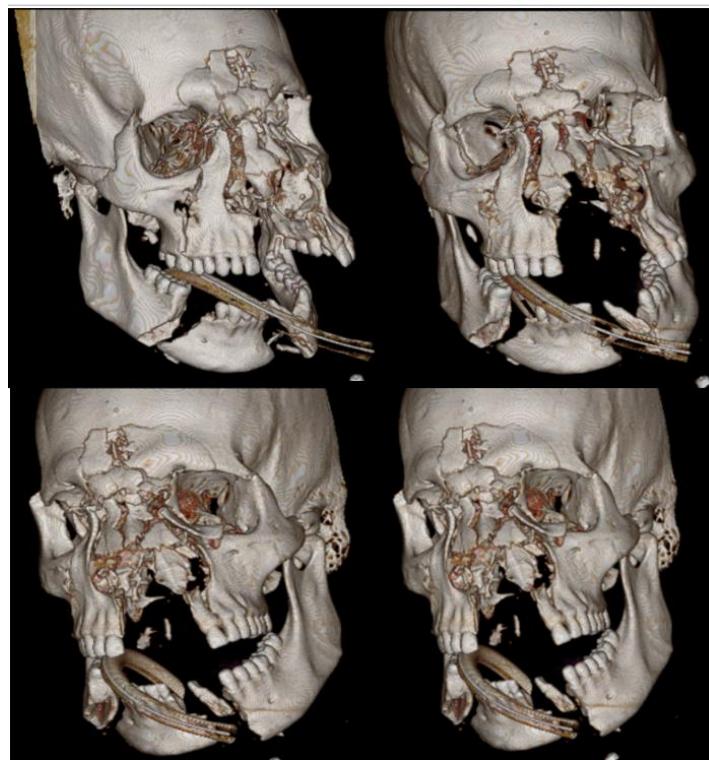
Facial CT revealed bilateral comminuted bone fractures of the mandible, maxilla, nasal, and orbits.
